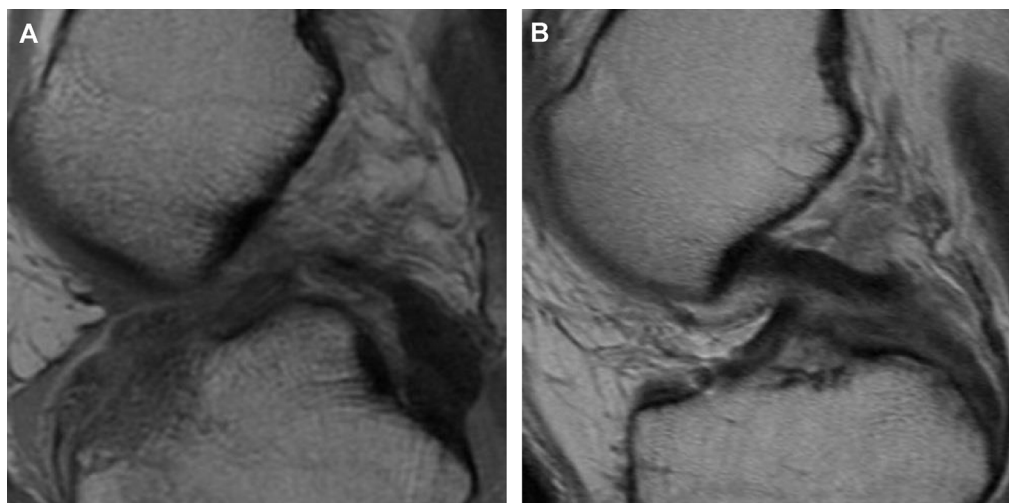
Preoperative MRI classification of the PCL injury. (A) Proximal injury and the remnant is detected mainly distally (Type P): 9 knees. (B) Distal injury and the remnant is detected mainly proximally (Type D): 13 knees.
